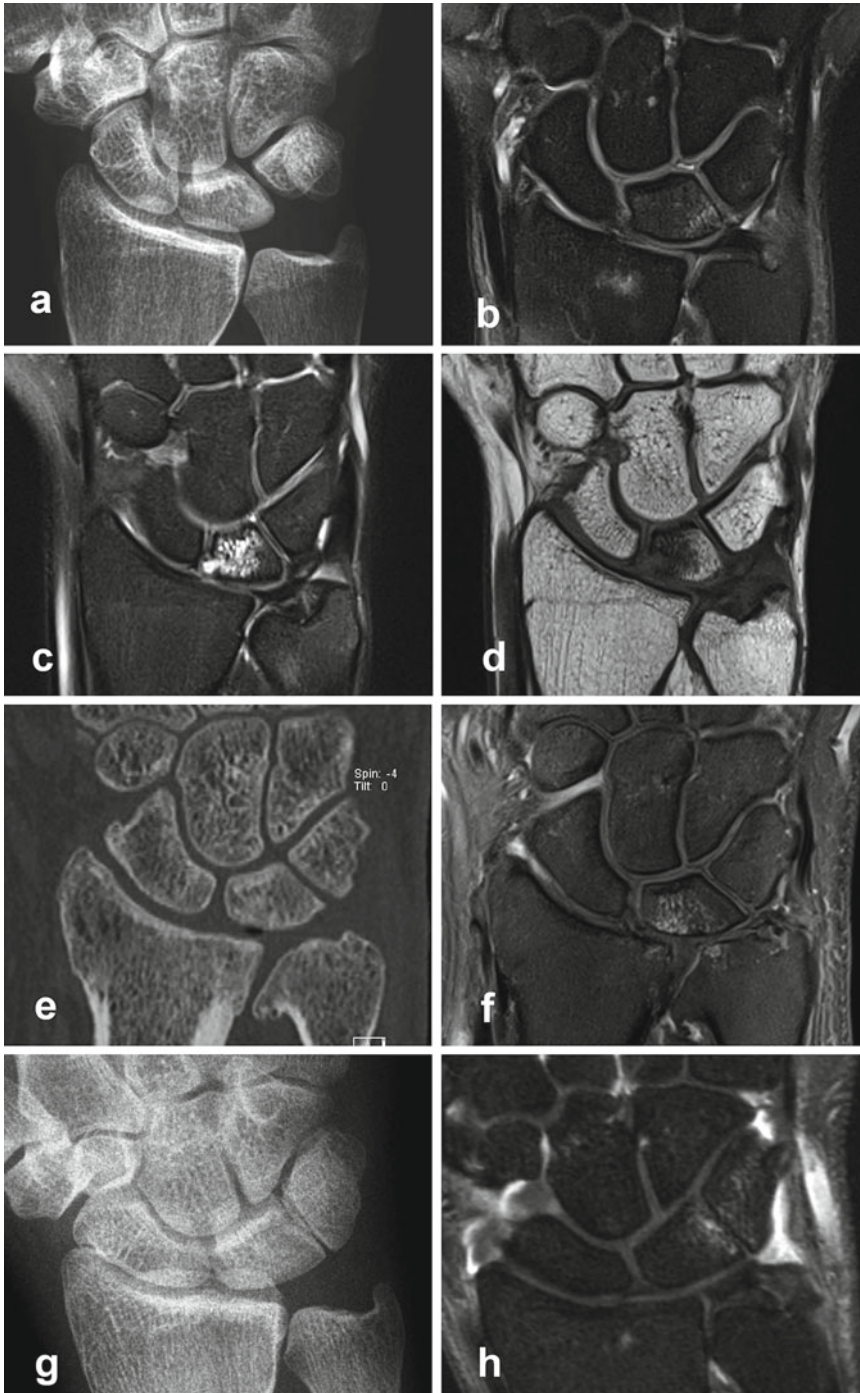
Differential diagnoses of Kienböck's disease. (a, b) Ulnar carpal impaction syndrome. Patient is a 44-year-old female with ulnar-sided wrist pain. Dorsopalmar radiograph is unremarkable. In fat-saturated PD-w FSE, subchondral bone-marrow edema is located at the proximal-ulnar circumference of the lunate. This ulnar-sided edema is different in localization from radial-sided
